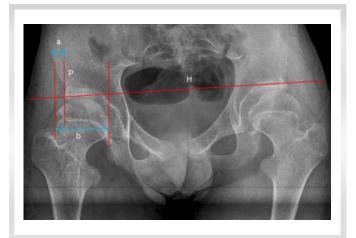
X-ray depicting calculation of migration percentage
